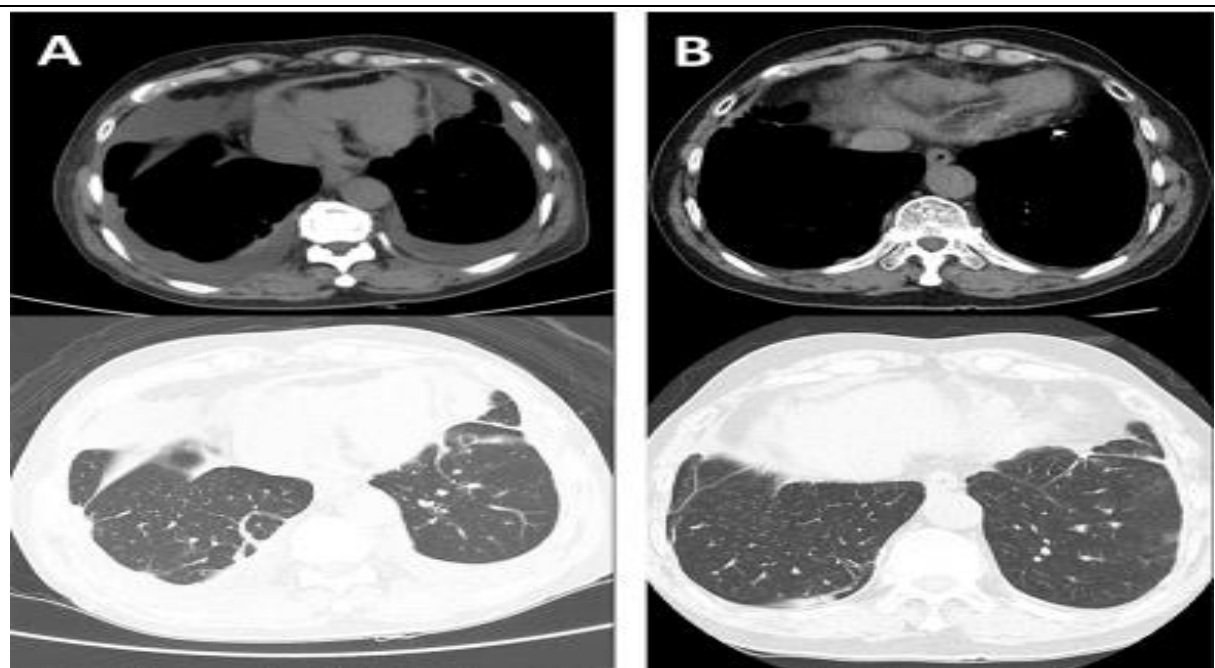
HRCT imaging. The results of the chest computed tomography revealed a modest amount of pericardial effusion, bilateral pleural effusion with some longitudinal consolidation, and a calcified granuloma within the pleura in the left lower lobe (A). After surgery, there was an improvement in pleural effusion, pericardial effusion, and linear consolidation (B).
